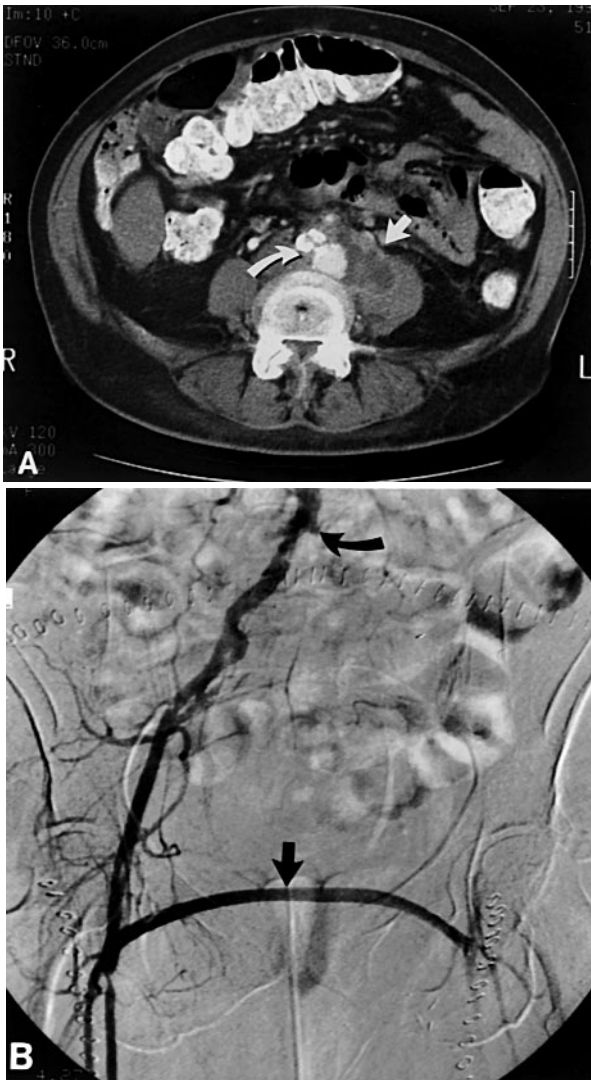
Infected left iliac aneurysm in a 63-year-old woman. A, *Curved arrow* in CT scan shows the saccular common iliac aneurysm. *Straight arrow* points to attenuation in the psoas muscle as a result of purulent fluid, which was confirmed at operation. B, *Curved arrow* in arteriogram indicates ligated left common iliac artery at its origin. *Straight arrow* points to femorofemoral bypass graft.
